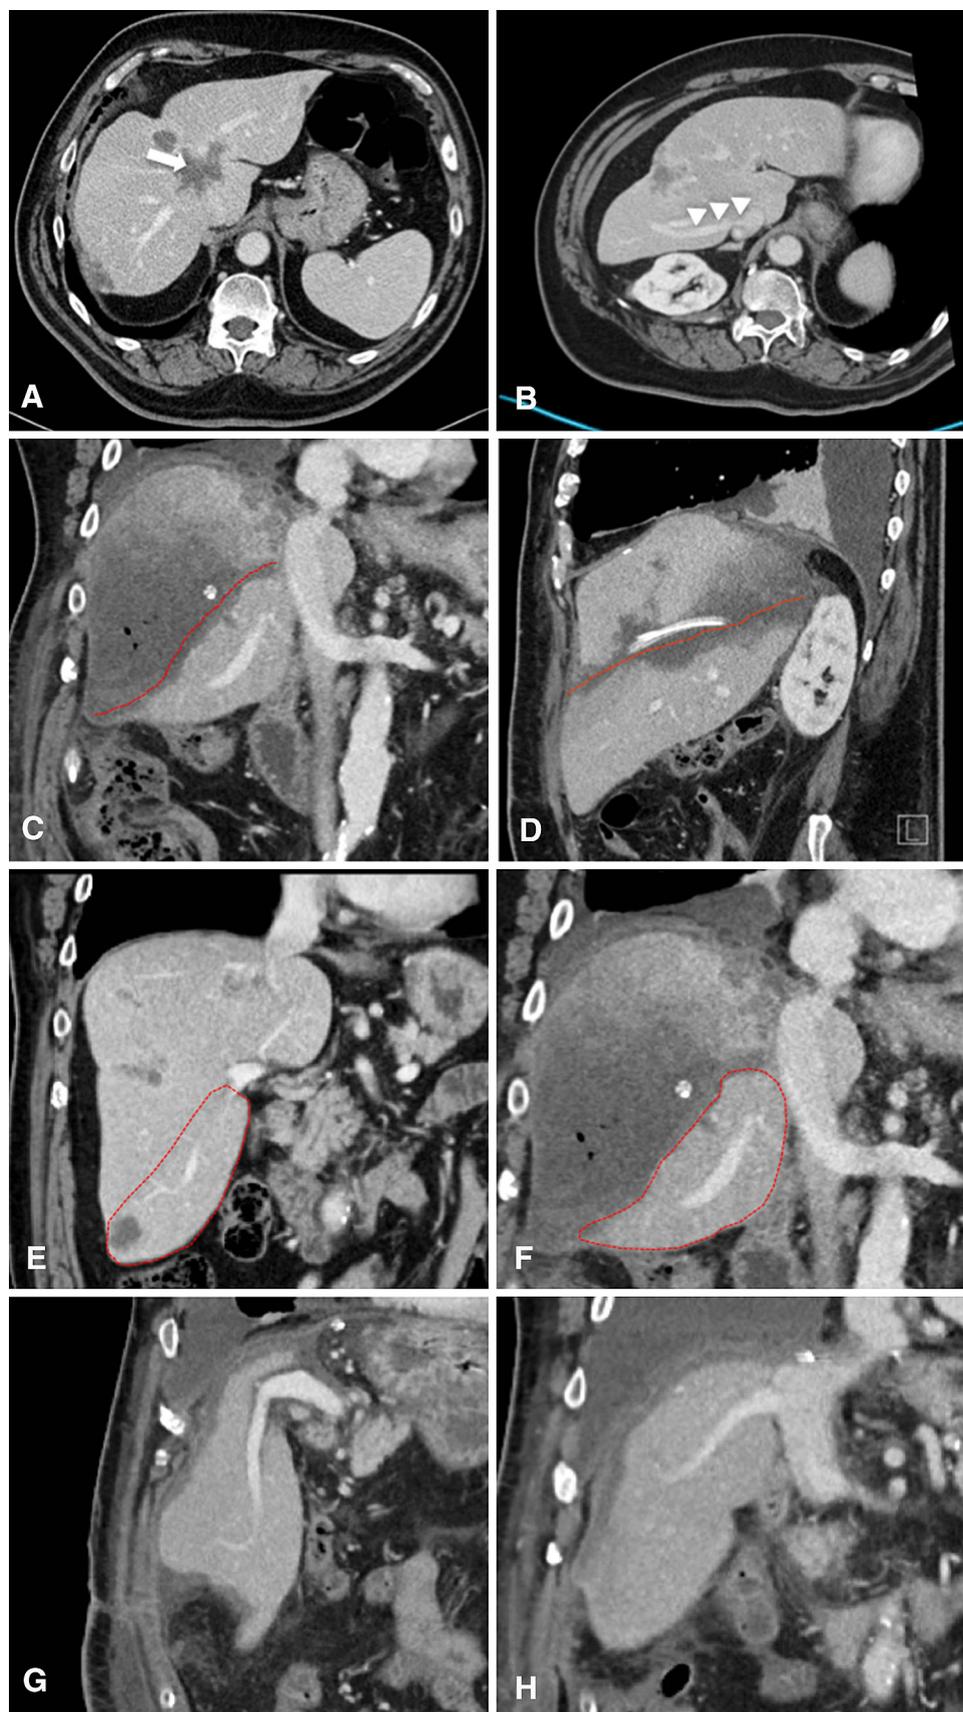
ALPPS variation: monosegment ALPPS: A 66-year-old man with colon cancer with multiple liver metastases. A In the preoperative images, there were 18 nodules, one of which had infiltrated the 3 hepatic veins (*arrow*). B Preoperative images also indicated a venous anatomical variant (*arrowheads*) in which segment VI was drained by an accessory vein directly into the inferior vena cava (accessory right hepatic posterior vein). Segment VI had 3 nodules. Because of this variant, the ALPPS procedure was performed to isolate part of segment VI. Coronal- (C) and sagittal (D)-enhanced CT images indicate the liver partition (*red dotted line*) separating part of segment VI from the rest of the liver. E Prior to ALPPS (IM1), the total liver volume was 1560 cm³, and the remnant liver (*red dotted lines*; segment VI) was 370 cm³ in volume (23% of the total liver volume). F Coronal CT images 12 days after S1. Segment VI increased in volume (*red dotted lines*) from 370 to 520 cm³ (an increase of 40%, which represents 33% of the total liver volume). Coronal images from follow-up-enhanced CT 4 weeks after hepatectomy demonstrate the remnant liver (segment VI), with its portal branch (G) and accessory right hepatic posterior vein (H).
